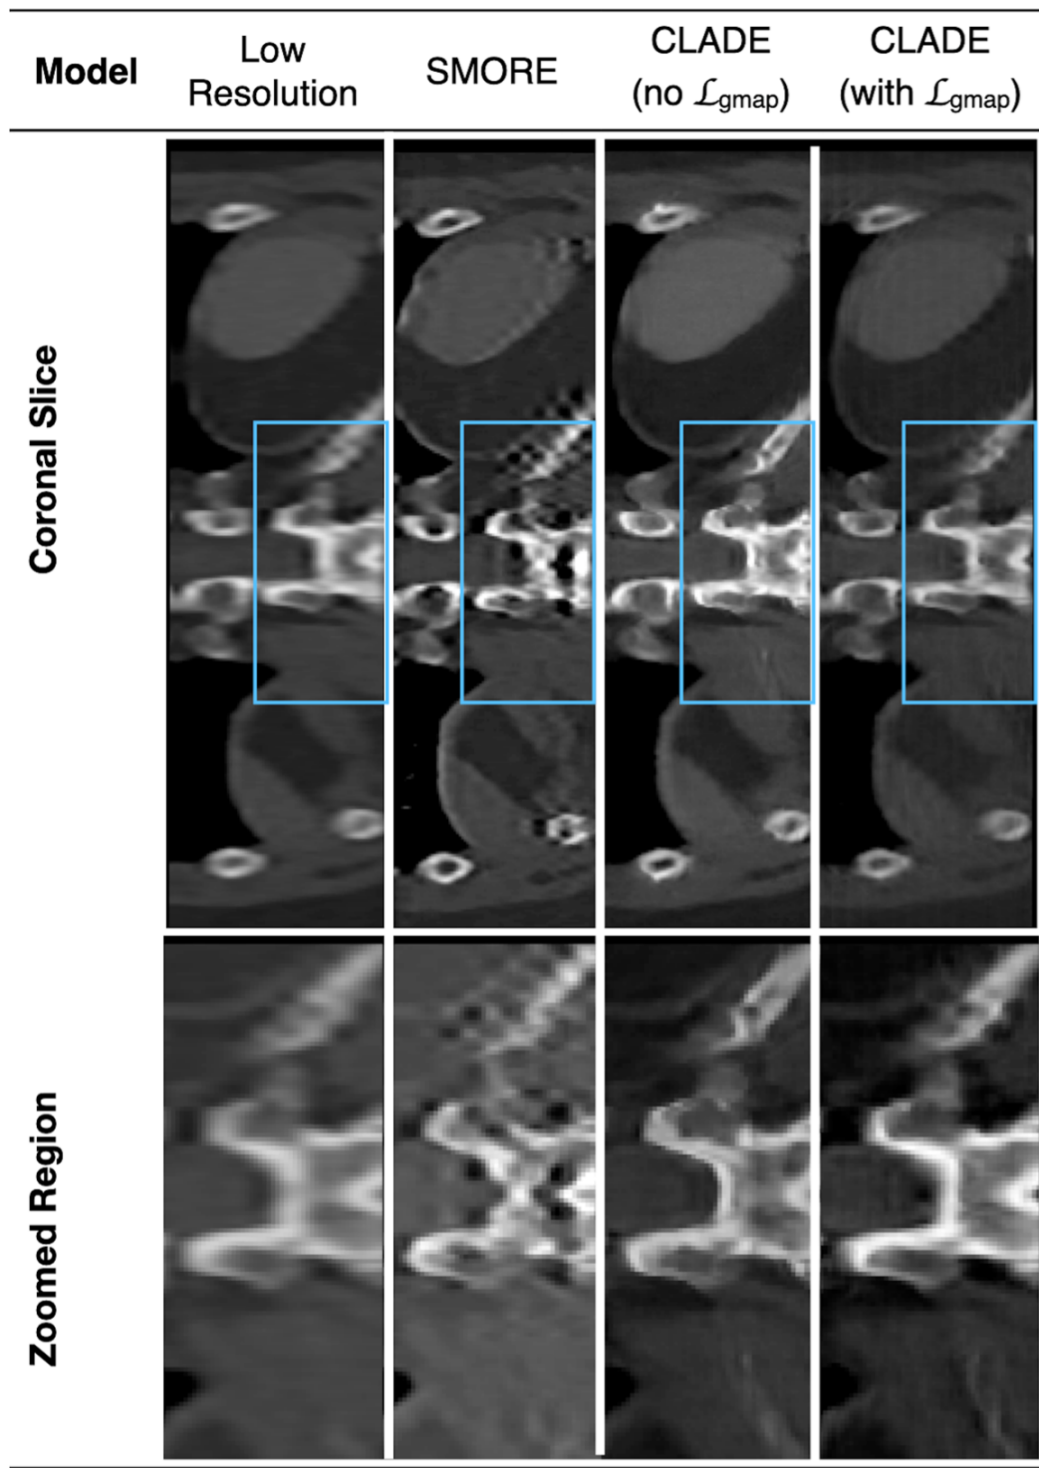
An example of coronal image quality from SRR applied to a low-resolution CT data from one subject in the test dataset. Note that the SRR models are applied in the low-resolution sagittal plane for the CT data, where this figure shows the resulting volume reformatted in the (low-resolution) coronal plane. Magnified regions within the blue box are displayed beneath each image.
